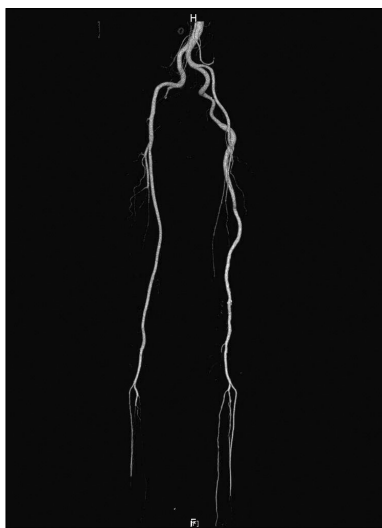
Immediate, postoperative computed tomography angiogram. Note the patency of the whole persistent sciatic artery and iliofemoral artery system. No residual thrombus was noted.
